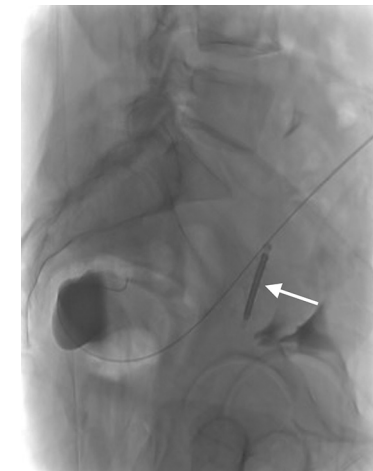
Lateral pelvic radiograph showing the wire directed into the rectouterine pouch, which is filled by contrast. The arrow marks the intrauterine device within the endometrial cavity
